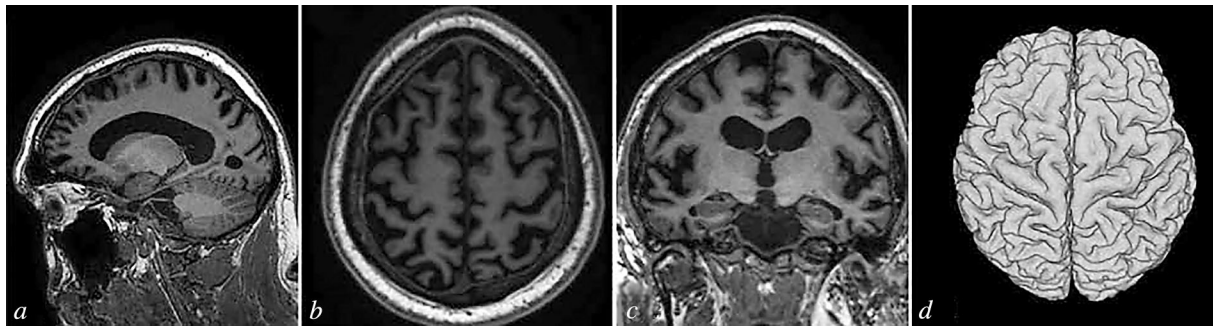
Brain MRI, T1-weighted images. *a*) Sagittal section. Cortical atrophy, most marked in the frontal and parietal lobes; *b*) axial section. Cortical atrophy, most marked in the frontal and parietal lobes; *c*) coronal section. Moderate decrease in the volume of the entorhinal cortex. Hippocampus volume preserved. Cortical atrophy in the frontal and temporal lobes; *d*) volumetric reconstruction demonstrating atrophic changes in the cerebral cortex.
